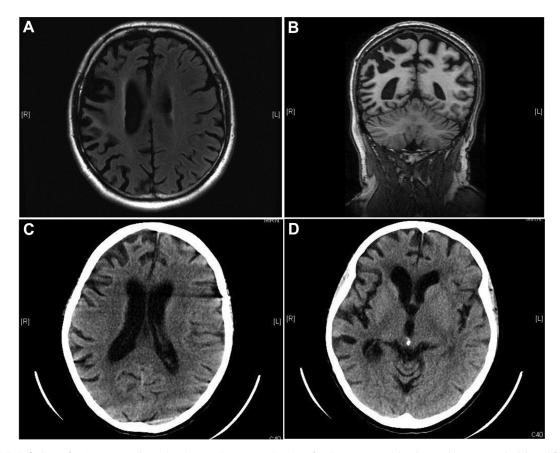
Neuroradiologic findings of patients III-3 and III-5. (A, B) Magnetic resonance imaging of patient III-3. T1 axial and coronal images reveal a bilateral frontal and parietal cortical atrophy, frankly asymmetrical (right > left). (C, D) Computed tomographic scans of patient III-5 show frontotemporal cortical atrophy, with prominent involvement of the right frontal lobe. Some motion artifacts are present.
